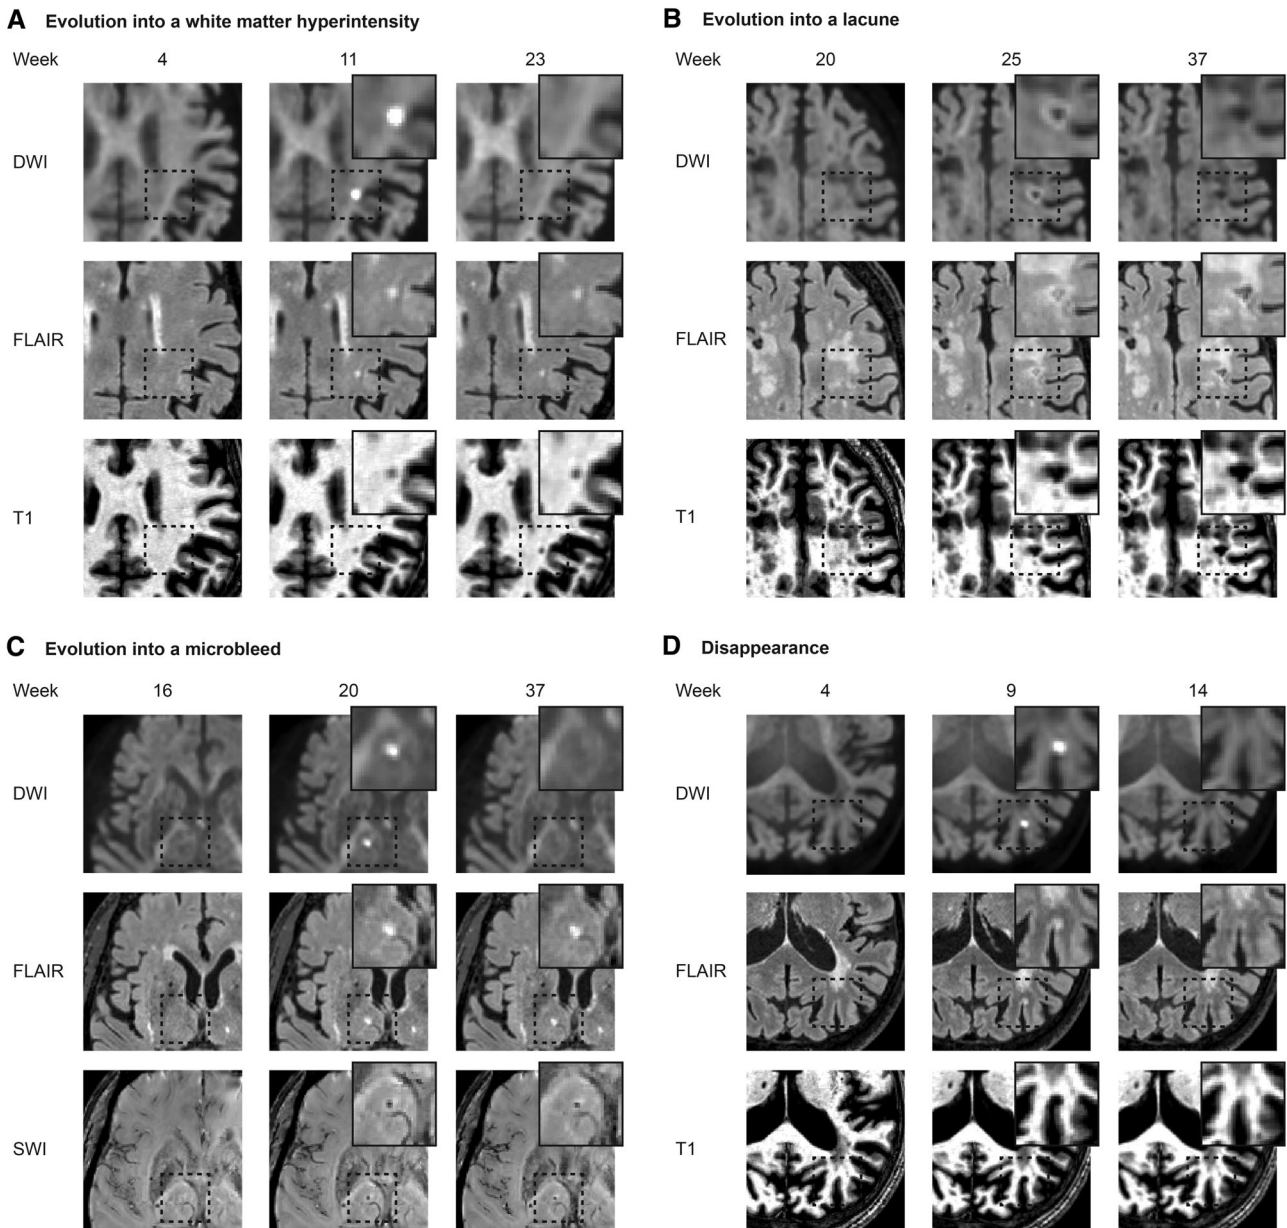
Differential evolution of diffusion-weighted imaging positive (DWI+) lesions. Each panel shows $b = 3,000$ DWI trace images. Prelesional scans (left) and last available follow-up scans (right) are shown. FLAIR = fluid-attenuated inversion recovery; SWI = susceptibility-weighted imaging.
